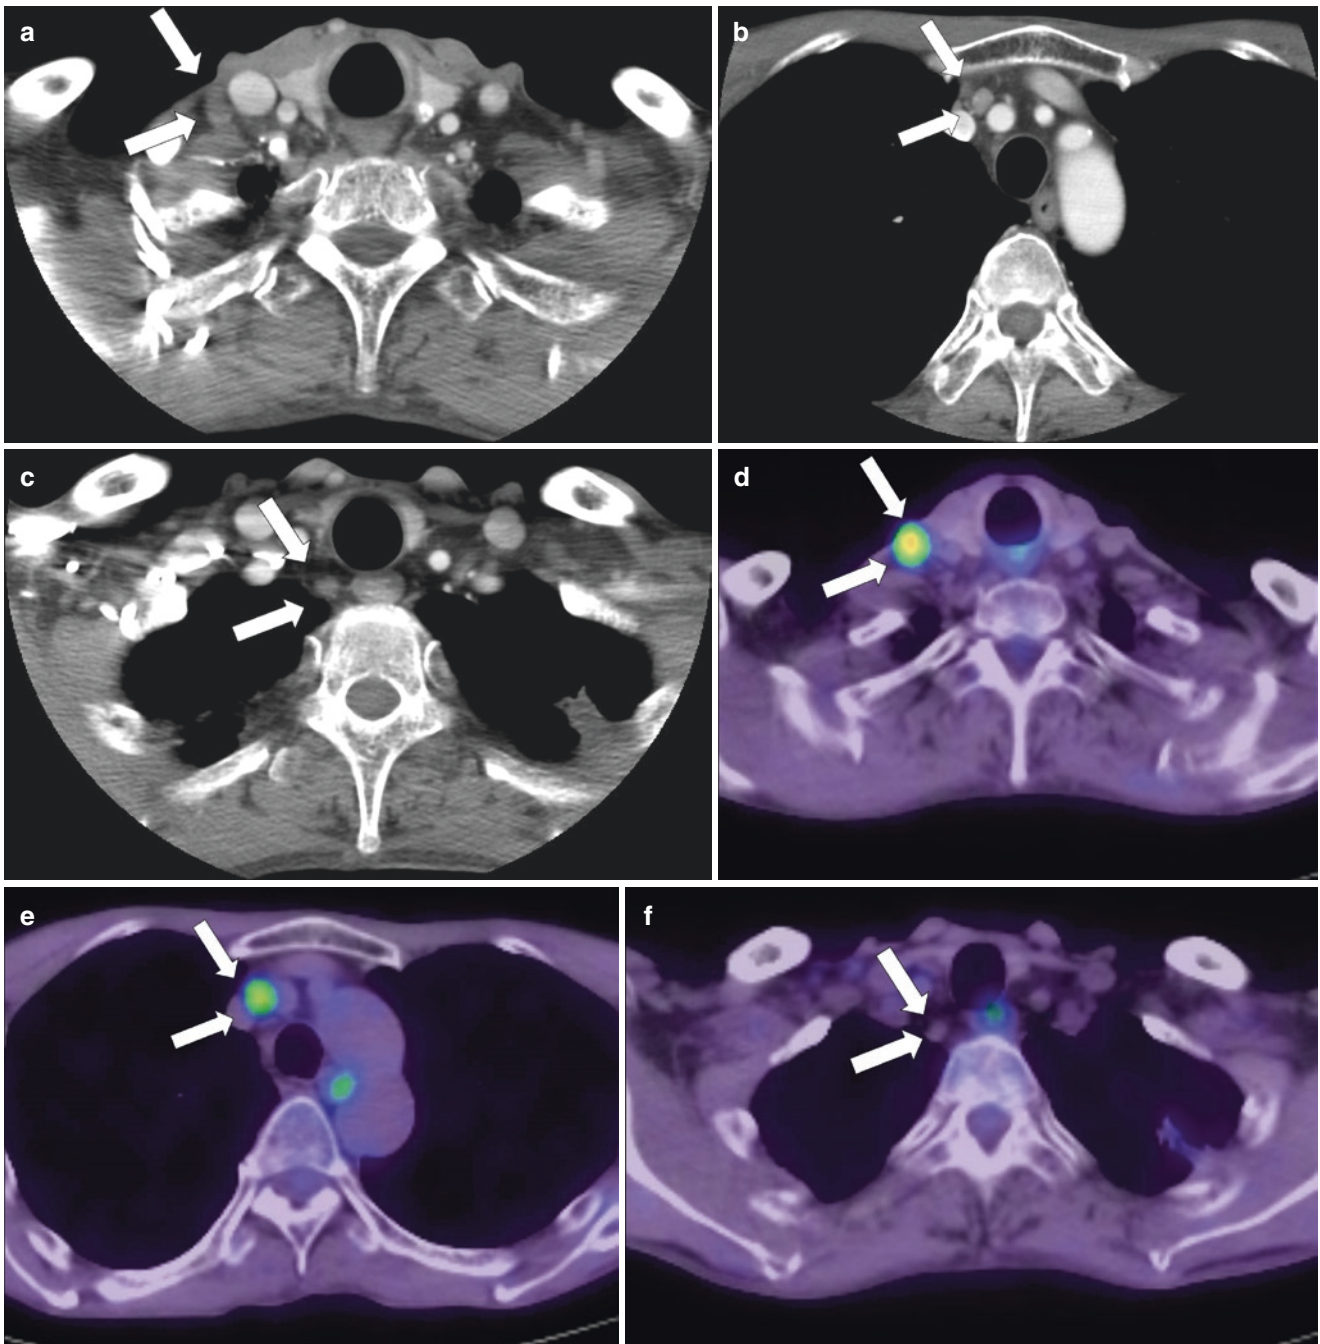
A 56-year-old man with hypopharynx squamous cell carcinoma. Contrast-enhanced CT showed three cervical adenopathies (a, b, and c, arrows). Out of three lymph nodes, two had significant FDG
